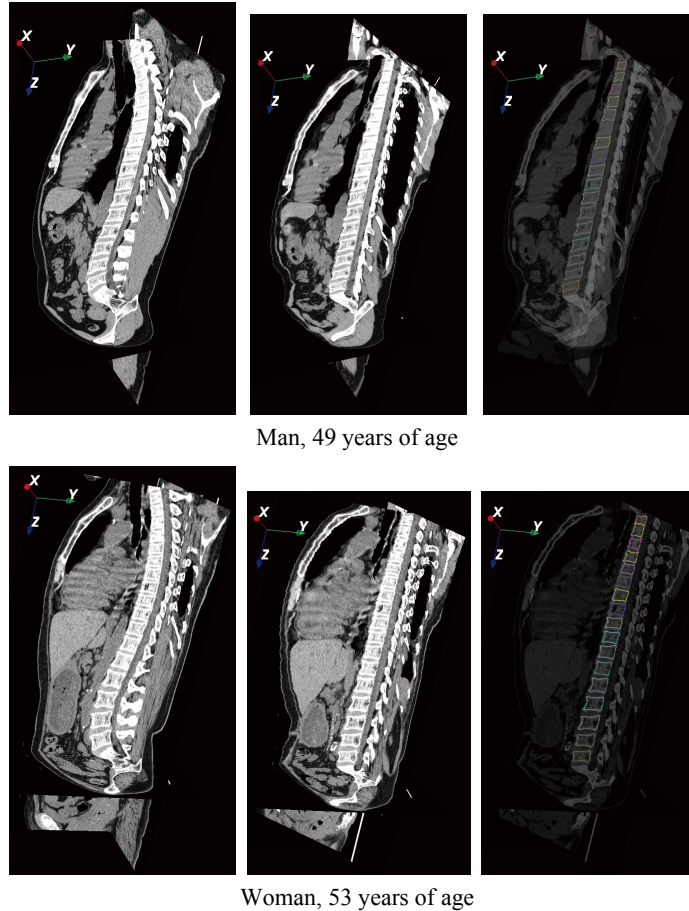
Experimental results from two cases. Left: Section view of CT images. Middle: Section view of the re-formed images. Right: Section view of the overlaid images between the re-formed images and points produced using the proposed scheme. Localization results of individual vertebral bodies are indicated in different colors.
